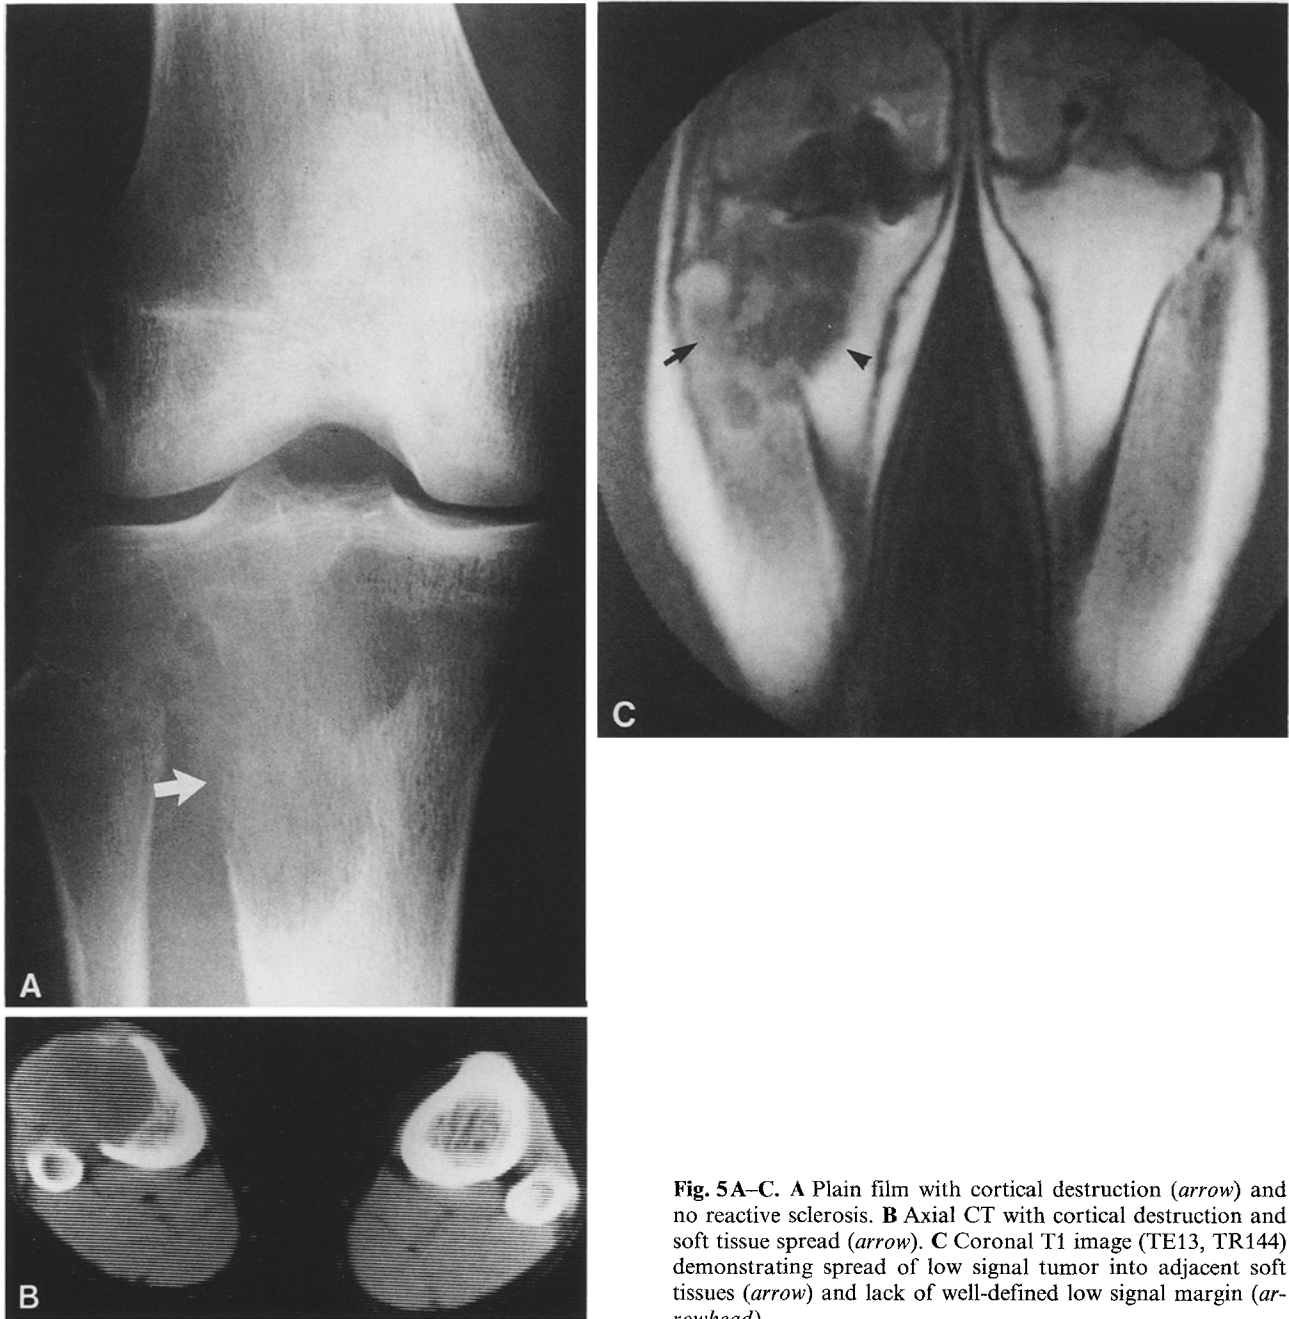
A Plain film with cortical destruction (*arrow*) and no reactive sclerosis. B Axial CT with cortical destruction and soft tissue spread (*arrow*). C Coronal T1 image (TE13, TR144) demonstrating spread of low signal tumor into adjacent soft tissues (*arrow*) and lack of well-defined low signal margin (*arrowhead*)
